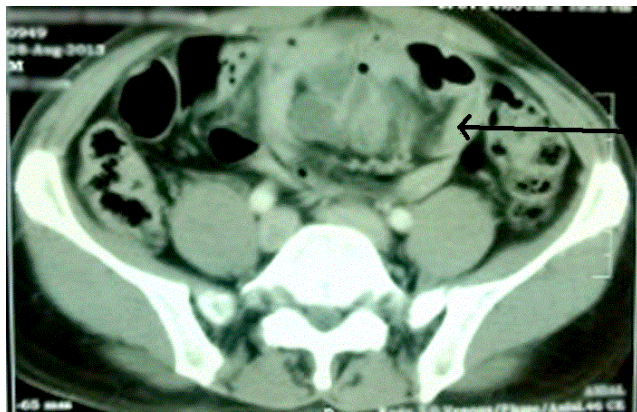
CT scan- Arrow showing fibrous membrane
